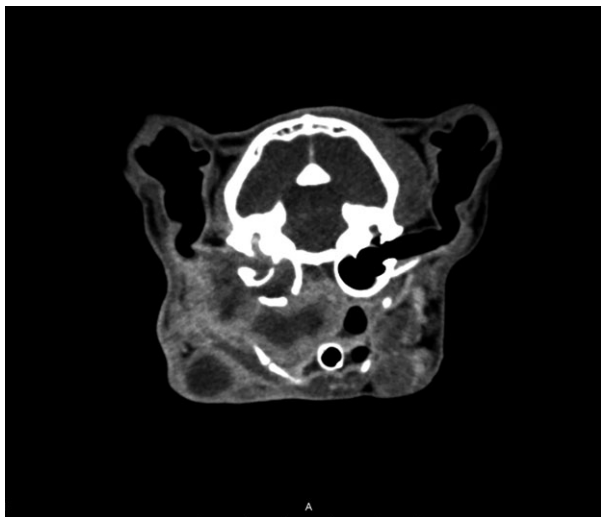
Computed tomography revealing fluid-attenuating, mildly enhancing soft tissue filling the right tympanic bulla and extending into the horizontal external ear canal, with multifocal lysis of the osseous bulla.
